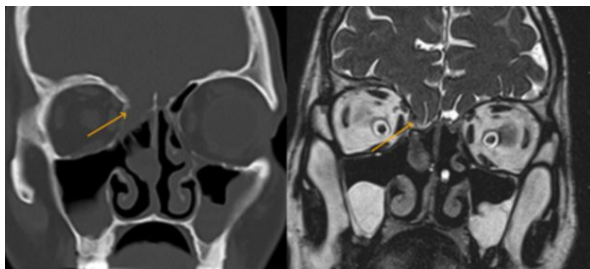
Post traumatic defect of the right ethmoid roof on HRCT. The coronal CISS sequence demonstrates a right frontal encephalocele.
